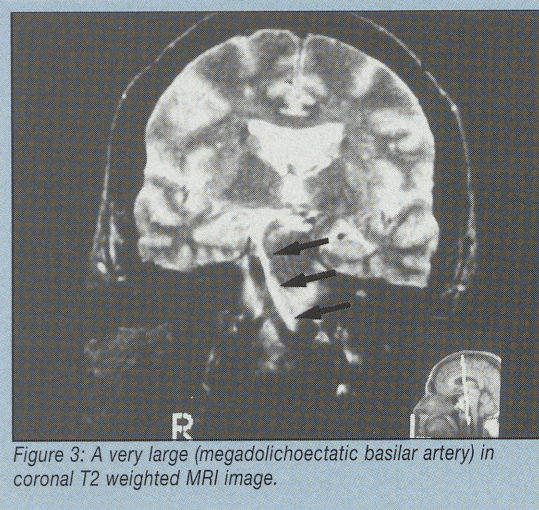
A very large (megadolichoectatic basilar artery) in coronal T2 weighted MRI image.
